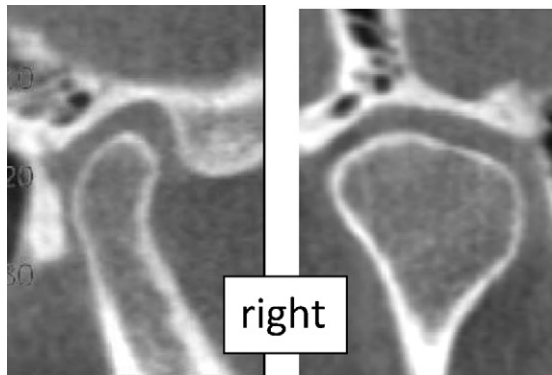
The cone-beam computed tomography (CT) images of a normal right TMJ is shown. Normal joints have condylar head bulge (condyle larger than neck), rounded surfaces, smooth and continuous cortex, and no subcortical cysts.
